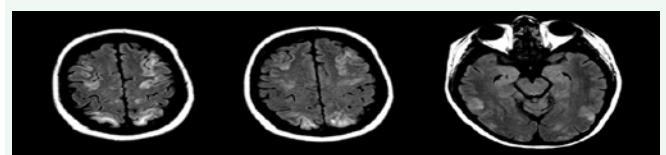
MRI brain, axial sections, with symmetric areas of abnormal T2/FLAIR signal intensity throughout the cerebral and cerebellar hemispheres, primarily involving the cortical and subcortical parenchyma.
